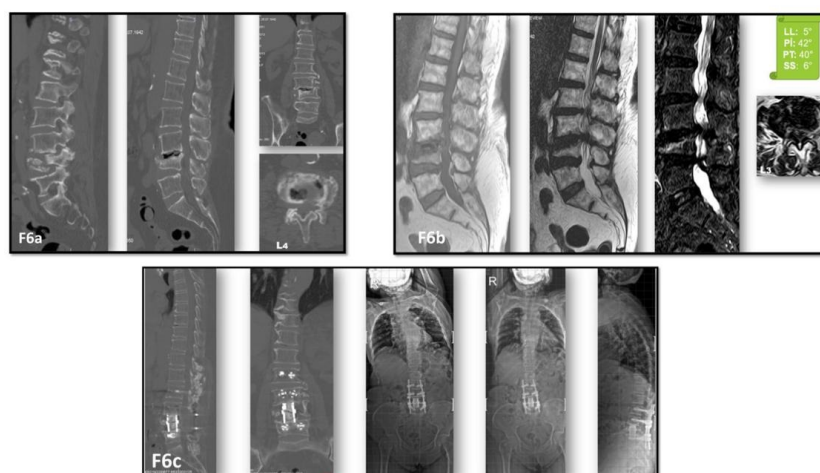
A-B. A 71-year-old female with a L4 osteoporotic fracture and lumbar spinal stenosis. C. A L4 PVCR with L2-L3-L5 instrumentation was performed. No problems were encountered in the control CT after 3 years. The patient died of natural causes 6 years after PVCR.
